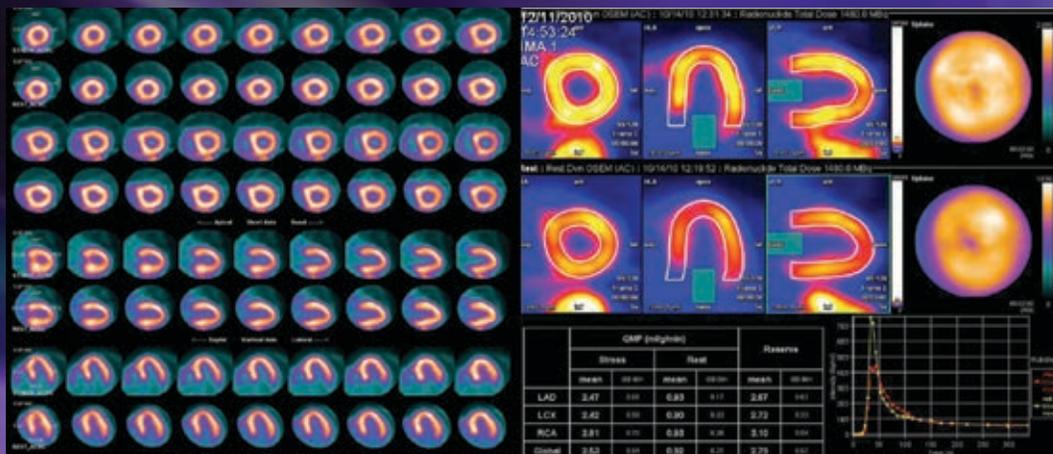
PET-CT protocol used at our institute using ⁸²Rb at both rest and then stress with adenosine.
